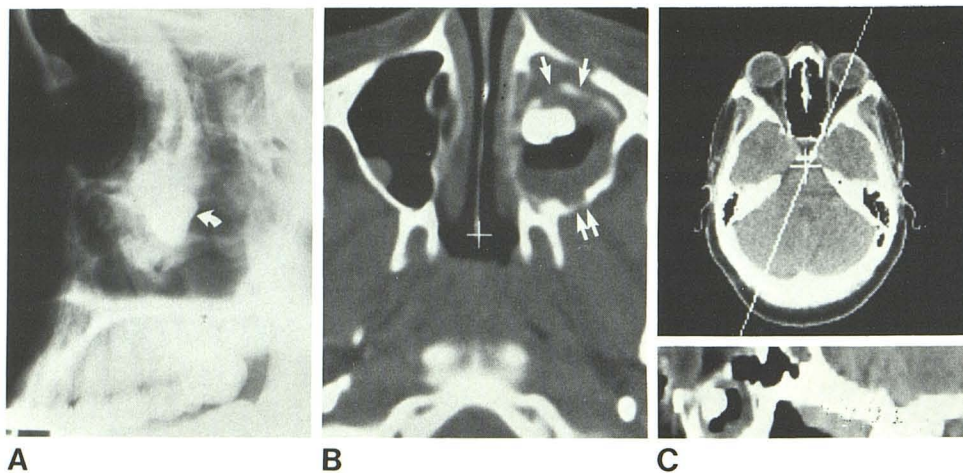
Dentigerous cyst in maxillary sinus. A, Tooth-shaped density near maxillary roof (arrow). B, Axial CT section. Cystlike structure (arrows) expands maxillary antrum, eroding its posterior wall. C, Reformation along midsagittal orbital plane shows extent of cyst to level of orbital floor. Surgery verified dentigerous cyst.
